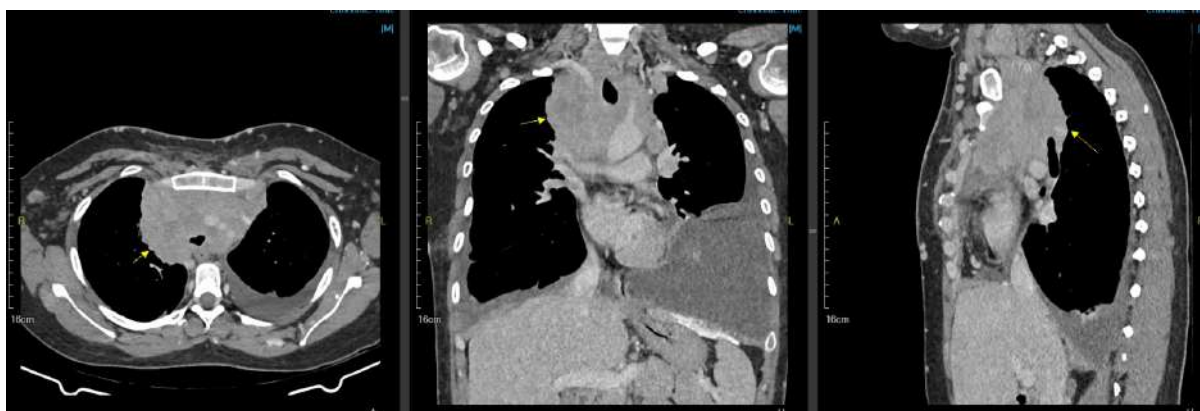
Results of a Contrast-Enhanced Chest CT Scan: A solid mass with necrotic components in the anterior mediastinum at the level of the thoracic vertebrae T1–T4, compressing and narrowing the superior vena cava at that level, causing tortuous dilation of the superficial veins of the right and left hemithorax extending to the right and left abdominal walls, and dilation of the inferior vena cava, consistent with the findings of malignant lymphoma.
